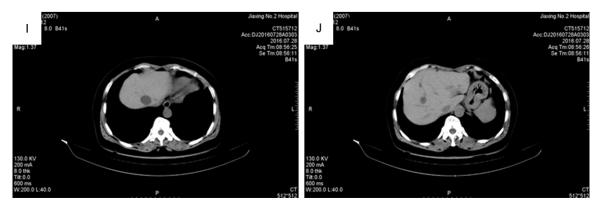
The contrast computed tomography imaging revealing multiple tumors in the liver (white arrow). A, B. Imaging on Dec 19, 2013. C, D. Imaging on Feb 27, 2014. E, F. Imaging on Dec 25, 2014. G, H. Imaging on Sept 24, 2015. I, J. Imaging on Jul 28, 2016.
